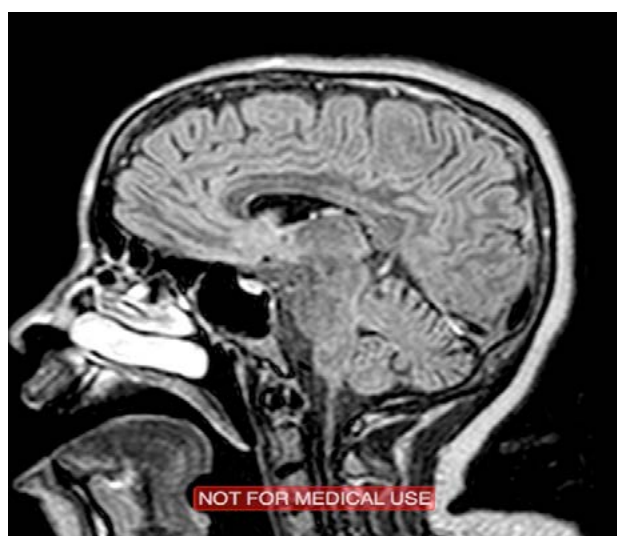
MRI Brain: sagittal, respectively, weighted FLAIR and T1 with gadolinium, demonstrating cerebellar atrophy, especially the vermis.
